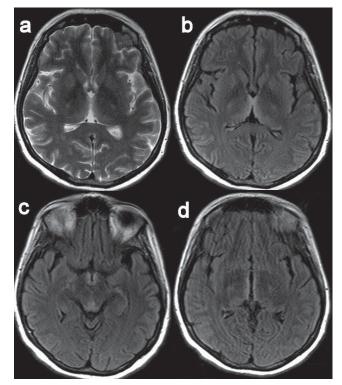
Axial fluid-attenuated inversion recovery (FLAIR) and spin echo (SE) T2-dependent images at baseline showed increased pathologic signaling in both medial thalamic regions (a), mammillary bodies (b), periaqueductal gray matter (c), and wall of the third ventricle (d).
